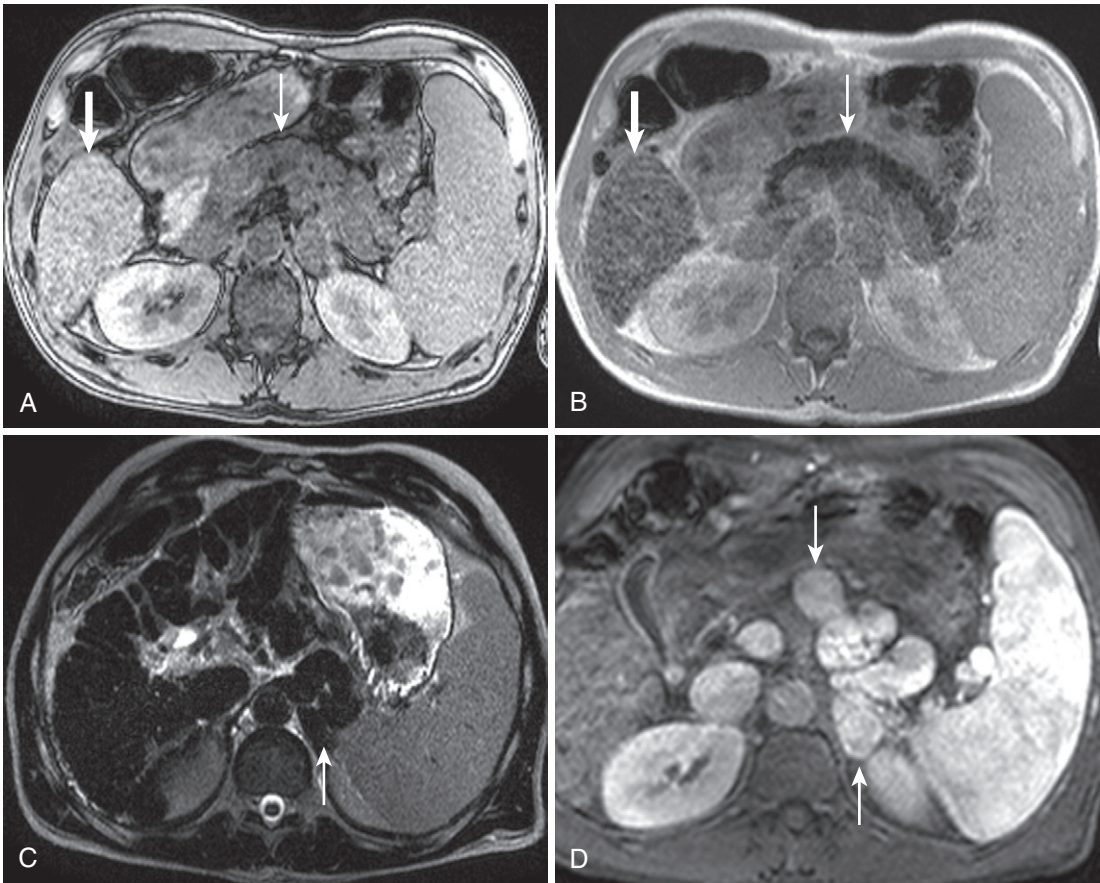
Primary hemochromatosis. The pancreas (*thin arrow* in A and B) and liver (*thick arrow* in A and B) drop in signal between the out-of-phase (A) and the in-phase (B) images, reflecting susceptibility artifact. C, The heavily T2-weighted image shows the characteristic nodular atrophy-hypertrophy pattern of cirrhosis (*arrow*). D, Note the tubular signal voids (*arrows*), which enhance on the delayed postcontrast image and correspond to massively enlarged portosystemic splenorenal collaterals (due to portal hypertension).
